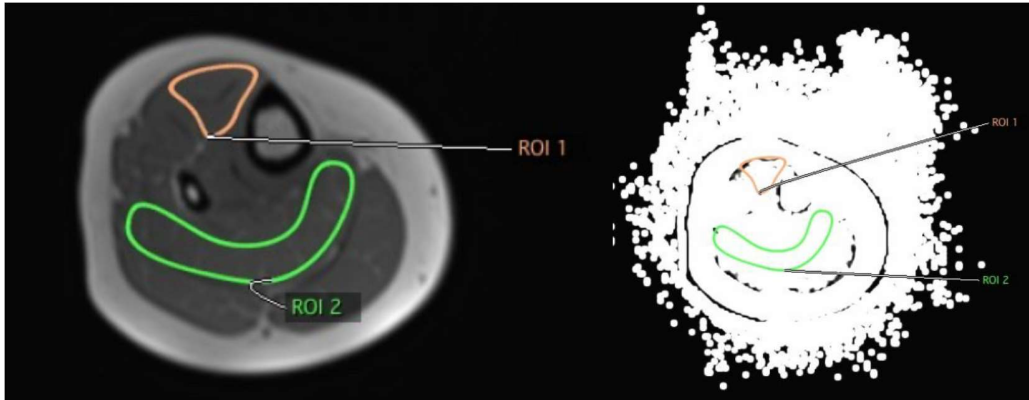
In- and Opposed phases of MRI-Dixon technique
